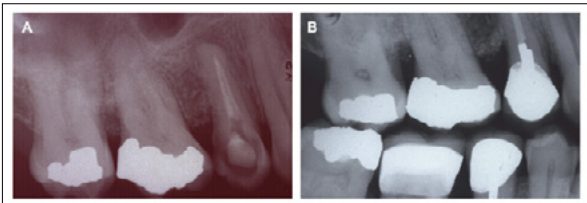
One-year post-treatment radiographs show fill of intrabony defects (A) and a resolution of the angular bony defect between the first molar and second premolar (B).
